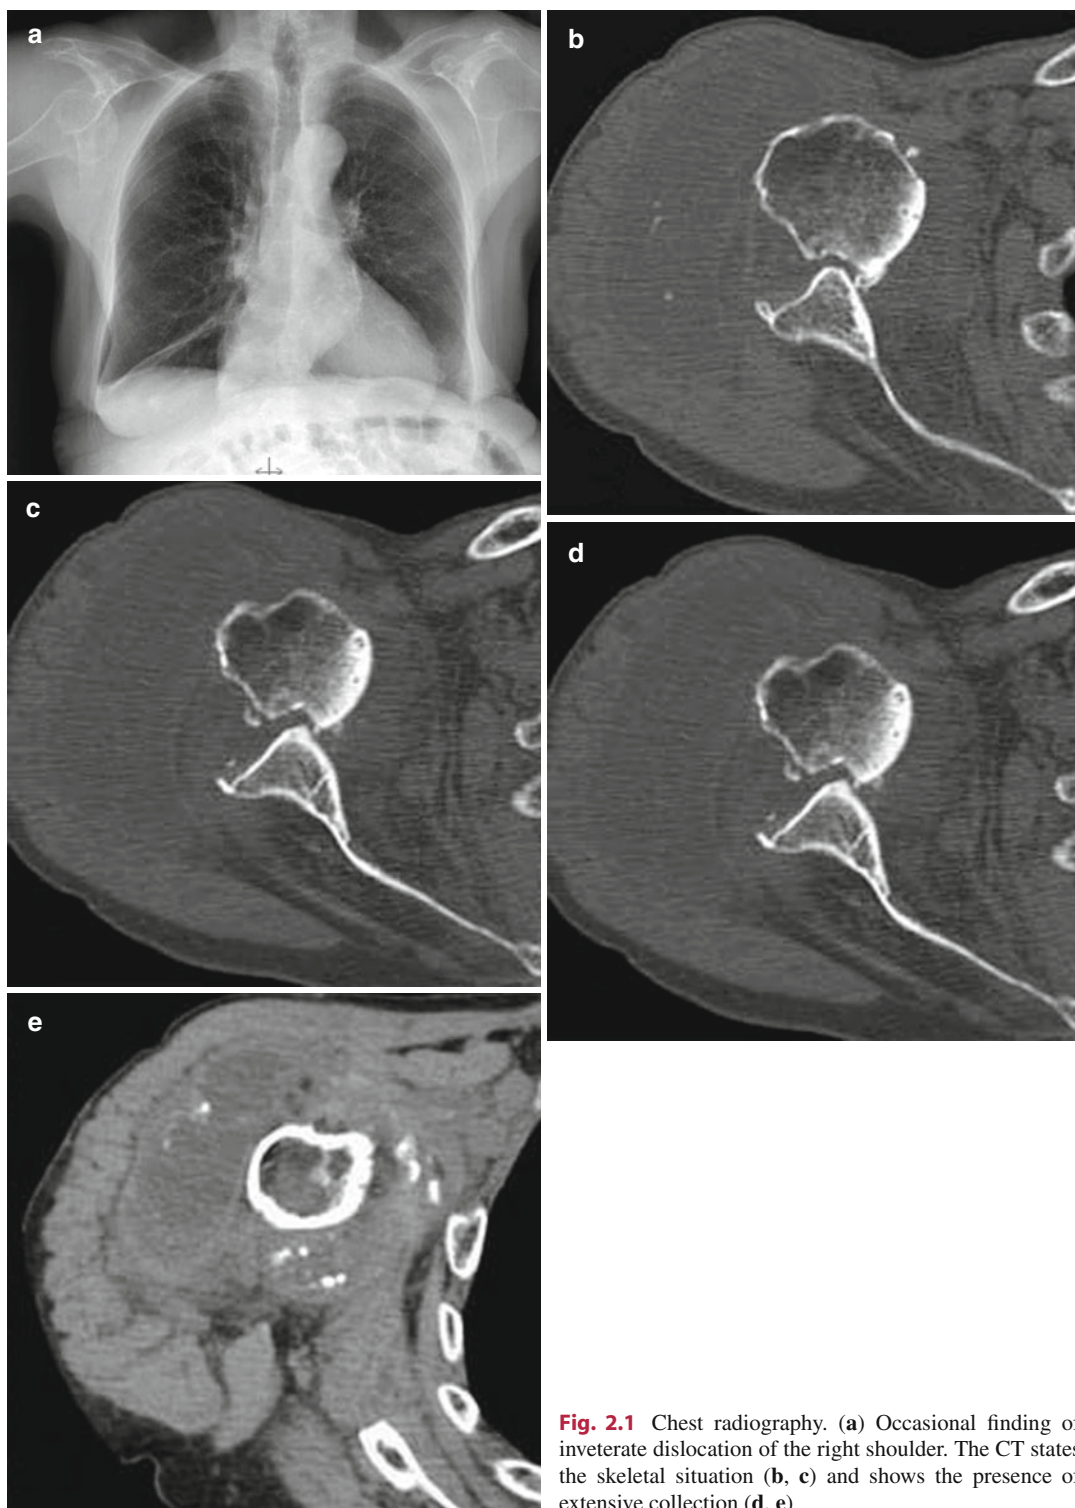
Chest radiography. (a) Occasional finding of inveterate dislocation of the right shoulder. The CT states the skeletal situation (b, c) and shows the presence of extensive collection (d, e)
